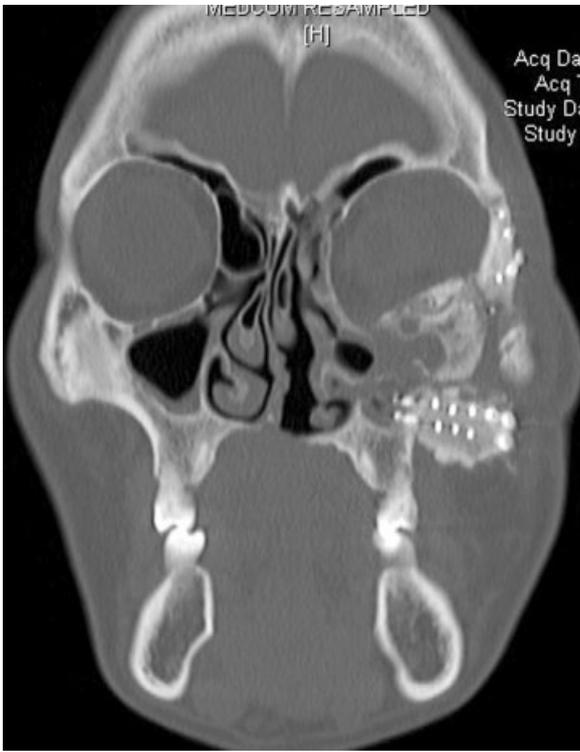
Coronal computed tomography image at 1 month postoperatively showing Norian CRS in situ and the iliac crest bone graft with minimal resorption.
